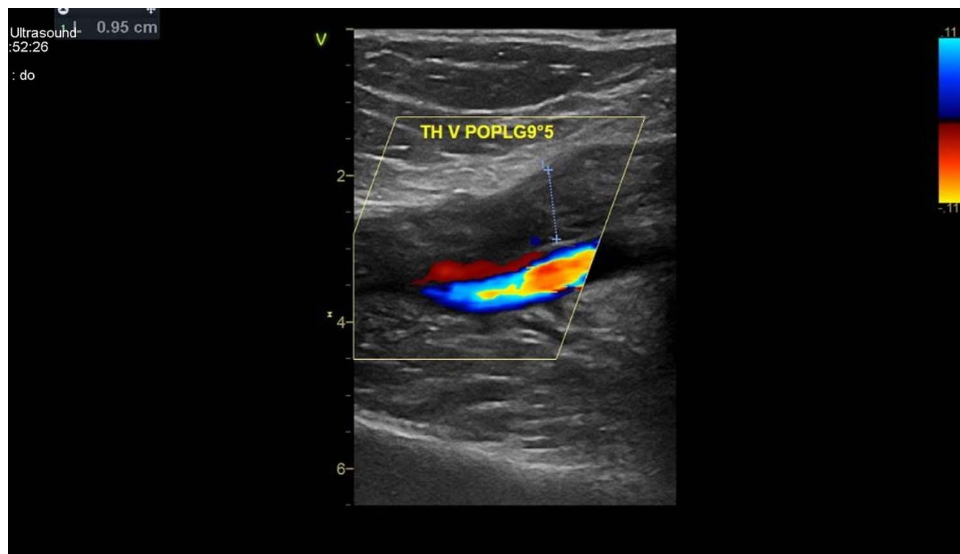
Lower extremity venous ultrasound showed a thrombus in the left popliteal vein.
